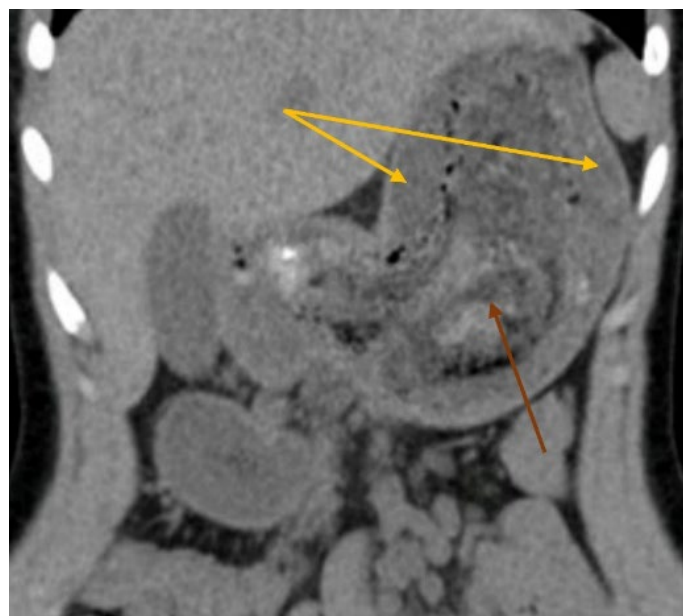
Abdominal CT scan: Frontal view. Stomach with swollen walls (orange arrows), due to inflammation, and containing a heterogenic trichobezoar (brown arrow).
